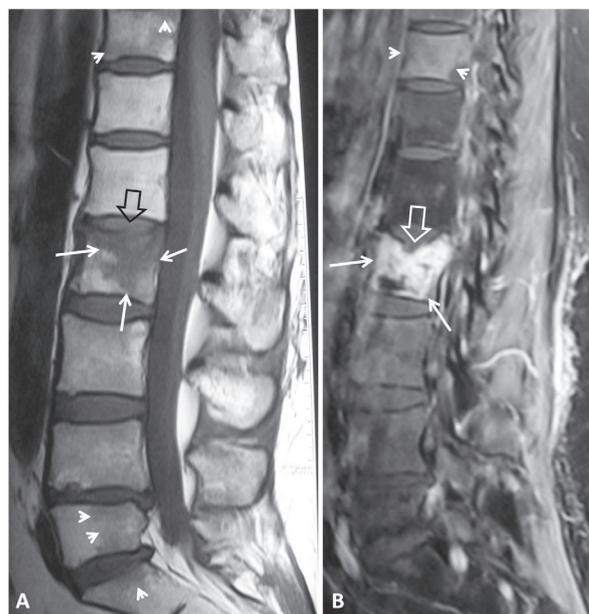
A 35-year-old female patient with primary multifocal spinal Hodgkin lymphoma. Sagittal T1w (A) MR image showing infiltration of the bone marrow of the L2 vertebral body (white arrows) along with a pathologic atraumatic fracture of the superior epiphyseal plate (black open arrow). Suspicious lesions are shown in the L5, S1 and T11 vertebrae (white arrowheads). Sagittal fat suppressed contrast-enhanced T1w (B) MR image shows intense enhancement of the abnormal bone marrow in the L2 vertebral body (white arrows), the collapse of the superior epiphyseal plate (white open arrow) and early infiltration of the T11 vertebra (white arrowheads). The suspicious lesions in the L5 and S1 vertebrae correspond to benign hyperplasia.
